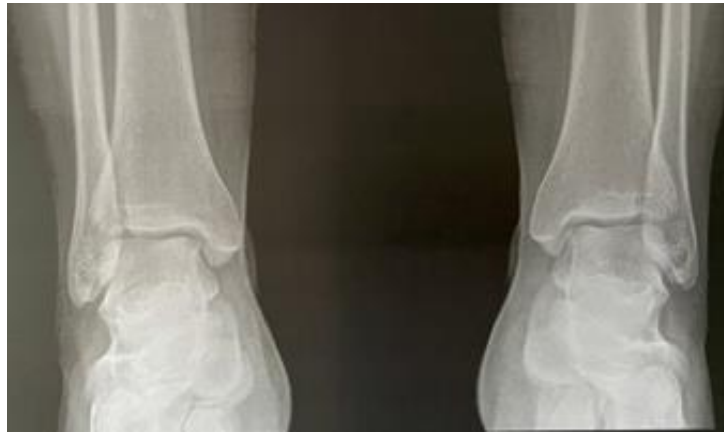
Absence of polycystic lesions in X-Ray
